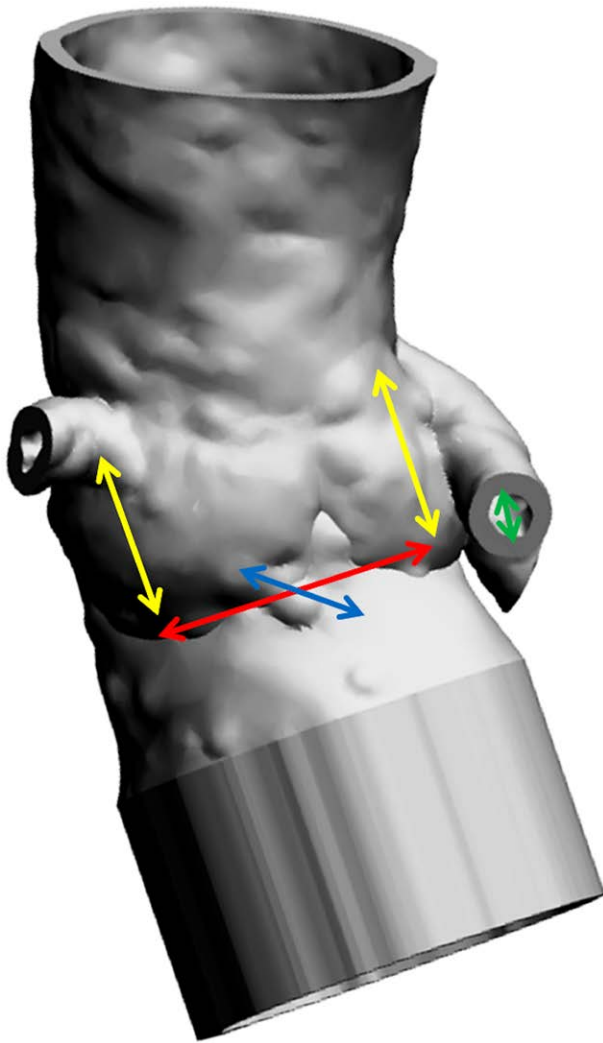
Three-dimensional-printed root models was validated by measuring and comparing, both on computed tomography (CT) scan images and 3D reconstructions, the sagittal and the coronal diameter of the aortic valve annulus (blue and red arrows), the distance between the aortic annulus and the coronary arteries (yellow arrows), and the diameter of the coronary ostia (green arrow).
